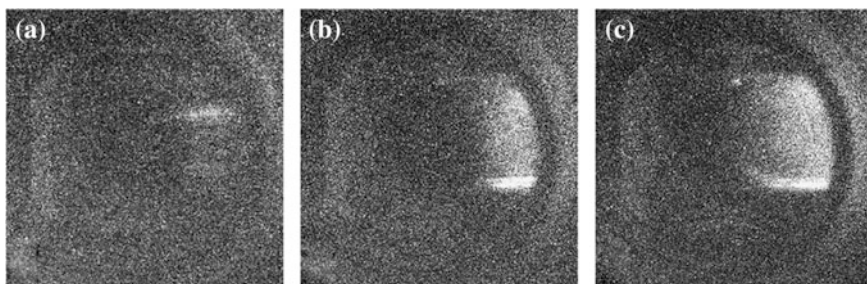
SL images acquired by an ICCD camera at the same exposure time (30 s) but with different electrical powers: a 30 W, b 50 W, and c 70 W. The ultrasound wave was transmitted from the *left* to the *right* side. Reproduced with permission from Cao et al. © Elsevier
